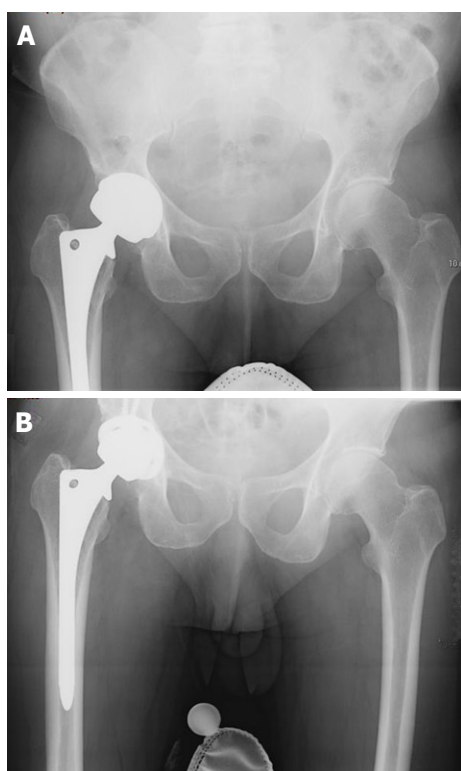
Pelvis radiograph of 56 year old male with a painful right metal-on-metal hip replacement (A). He complained of increasing groin pain and difficulty with ambulation. AP pelvis 6 mo after revision total hip replacement. The well-fixed femoral stem was left in place and the bearing revised to a metal-on-polyethylene bearing couple (B). The patient's preoperative symptoms resolved entirely.
